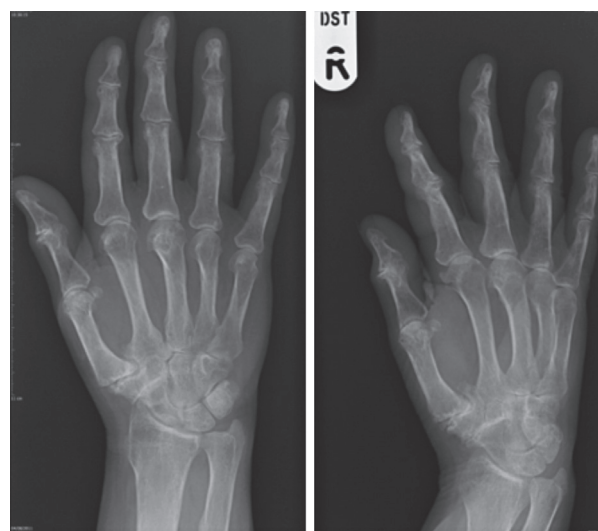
Pre-operative radiograph of one of the patients recruited in our study, demonstrating first CMC joint OA, grade 4 as per the Eaton-Littler classification.
